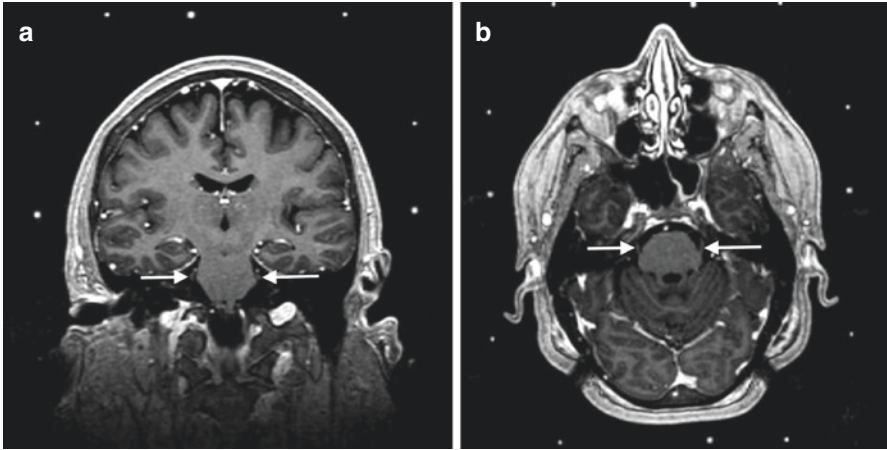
Coronal (a) and axial (b) images from a contrast-enhanced T1-weighted turbo field echo (TFE) data set performed for purposes of stereotactic guidance precisely depict each trigeminal nerve (arrows). Note the dots around the periphery of the field of view that serve as fiducial markers facilitating operative planning for Gamma Knife surgery
